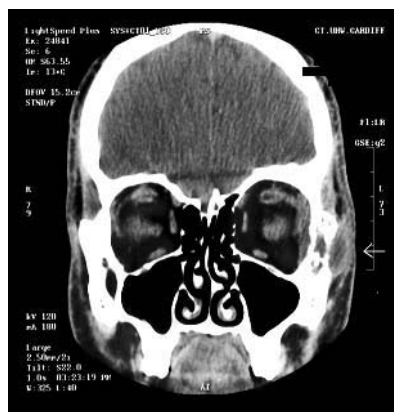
CT scan showing the osteolytic lesion in the lateral orbital wall.
